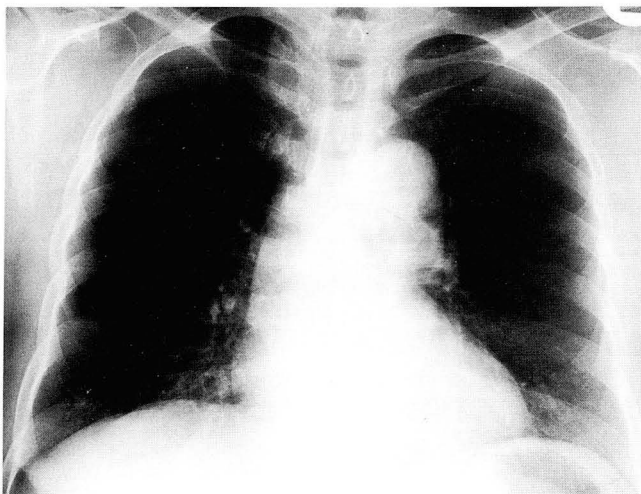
Posteroanterior radiograph shows a subtle polypoid mass in the trachea at the level of thoracic inlet.
